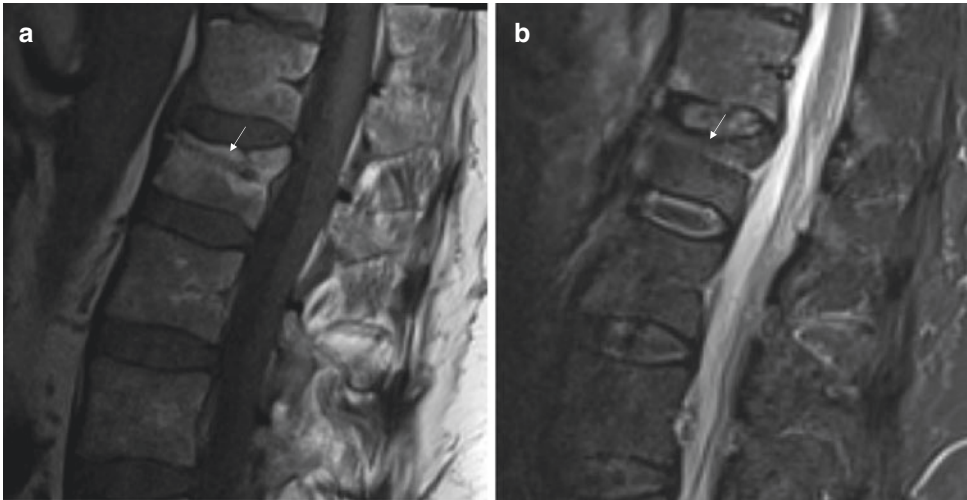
(a) Sagittal T1-weighted image demonstrates chronic T11 superior endplate depression with underlying hyperintense bone marrow signal, which suppresses on (b) STIR image, compatible with fatty change (white arrows)
